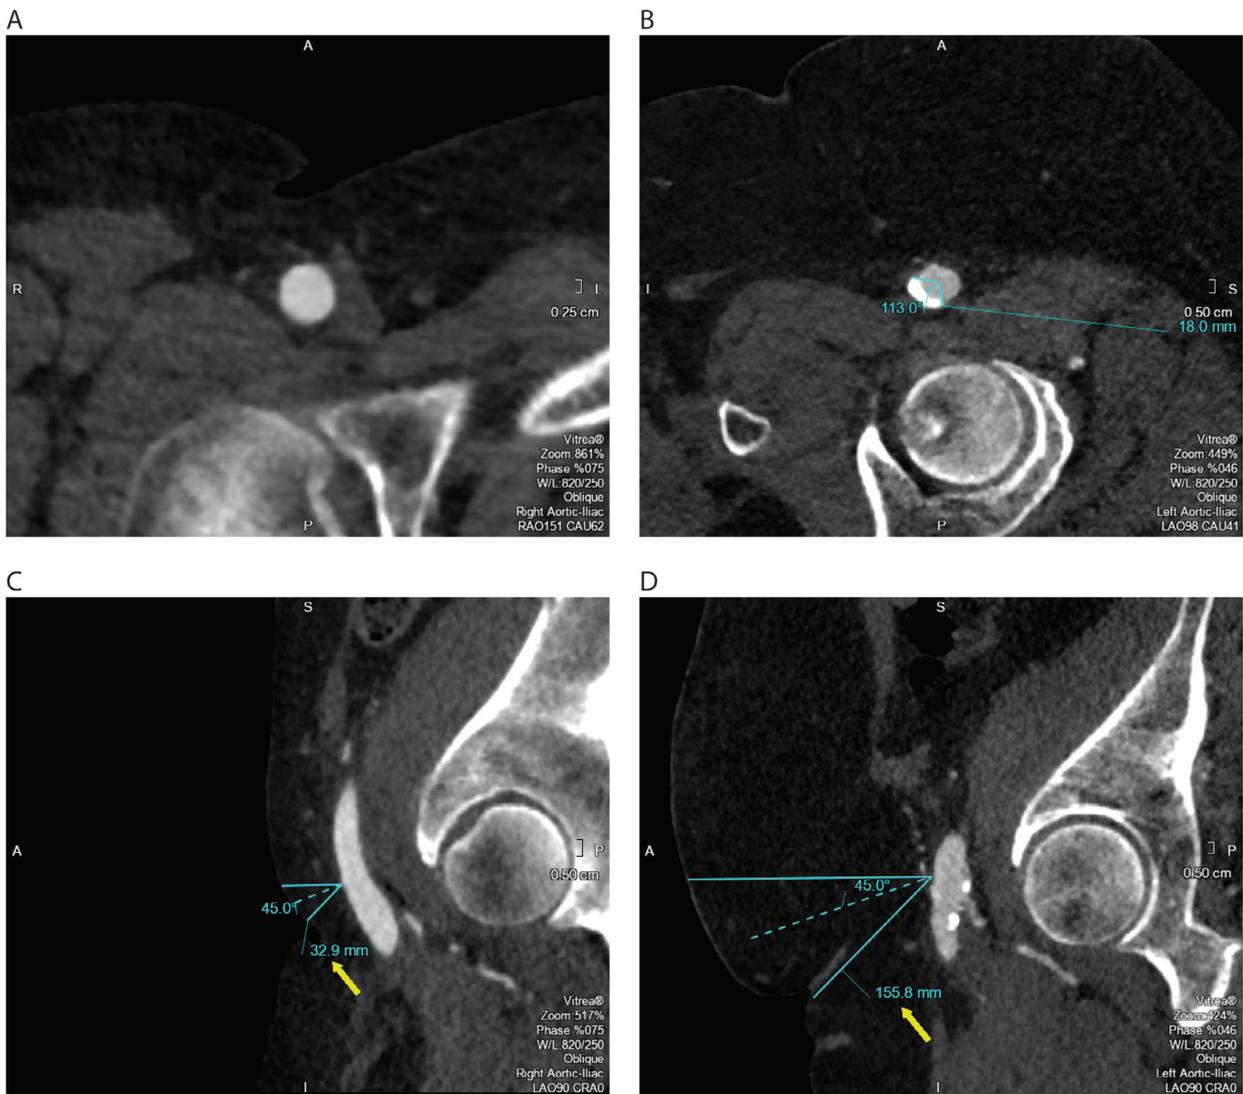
CTA measurements at the common femoral artery.
